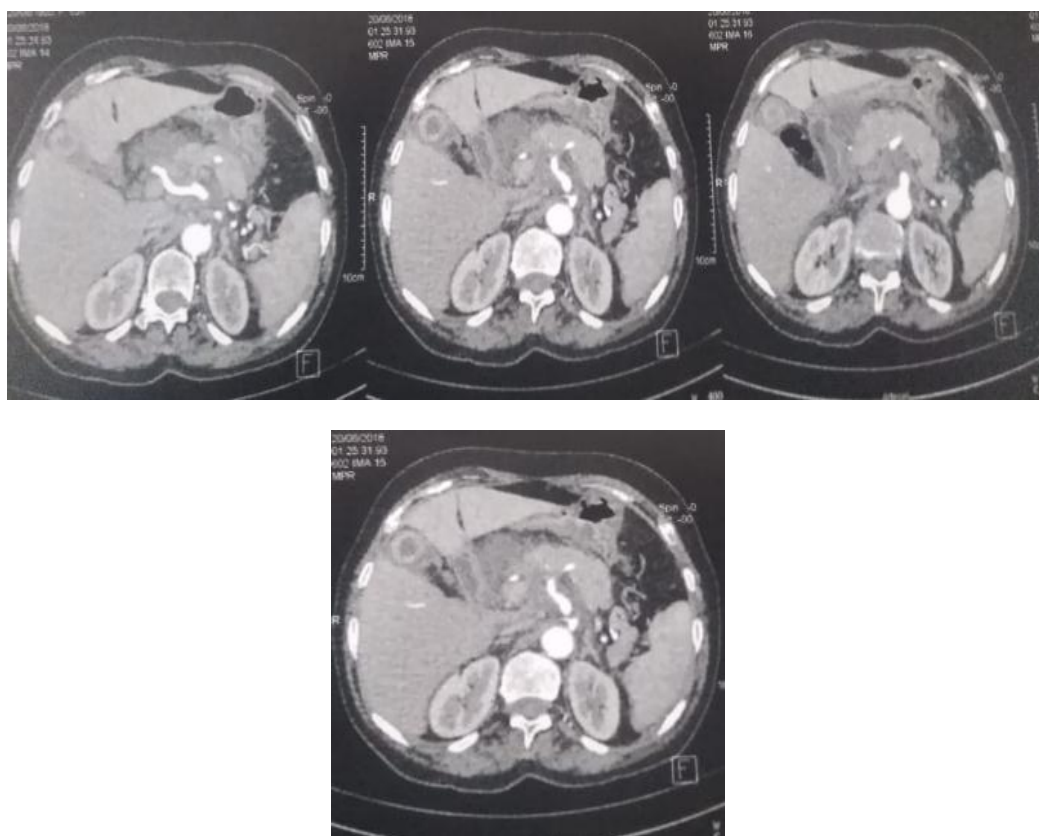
abdominal CT with injection of contrast agent shows an incomplete thrombosis of superior mesenteric vein, pancreatitis and vesicular lithiasis
